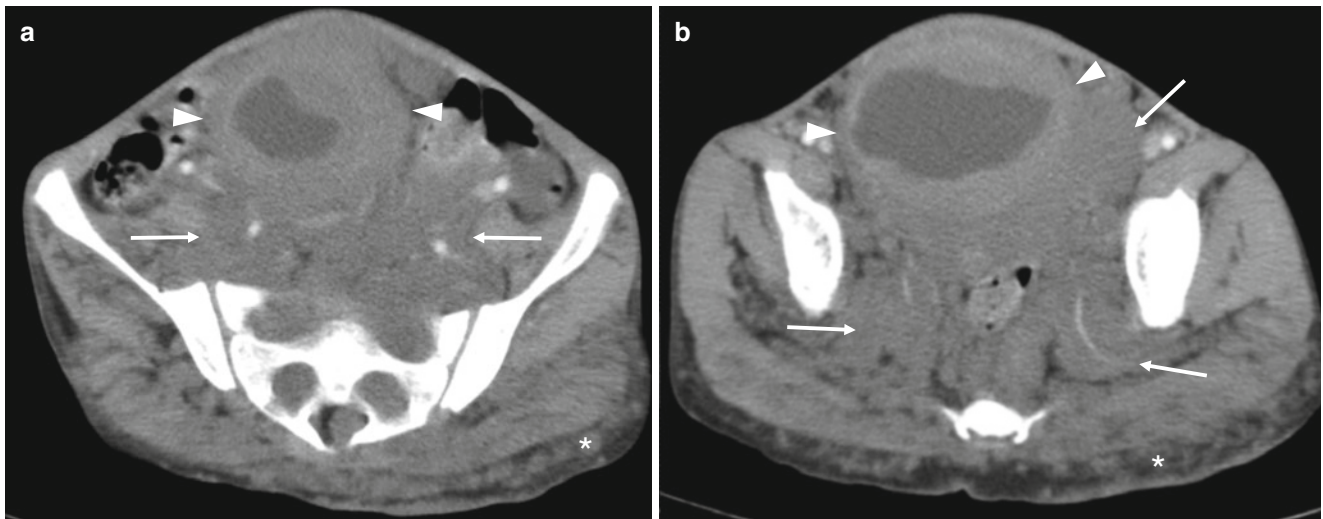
Neurofibromatosis with direct involvement of the bladder in a 7-year-old female. (a, b) Axial contrast-enhanced CT scans show large peritoneal masses (*arrows*) with widening of sacral neural foramina and extending to the pelvis outlet through the sciatic notch. Also
